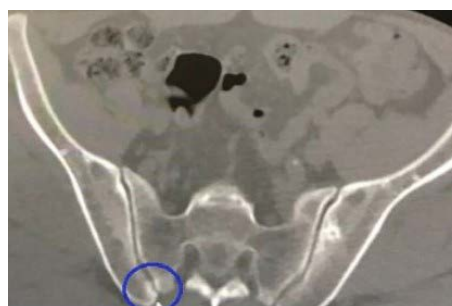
Image of right accessory sacroiliac joints at the S2 vertebra level on the axial computed tomography section in a 56-year-old man patient. A protrusion, extending from the iliac surface towards the sacral surface is observed.
